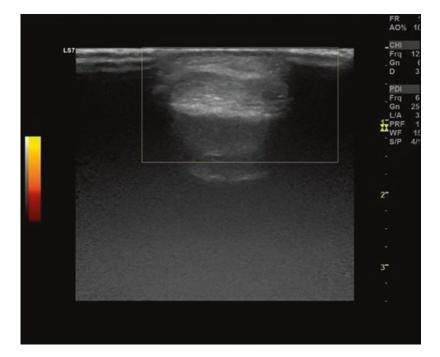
US image of a subcutaneous lipoma in the frontal region shows a compressible solid lesion within the subcutaneous adipose tissue with hyperechoic smooth contours compared to the adjacent adipose tissue. It shows lack of vascularization on color doppler USG
